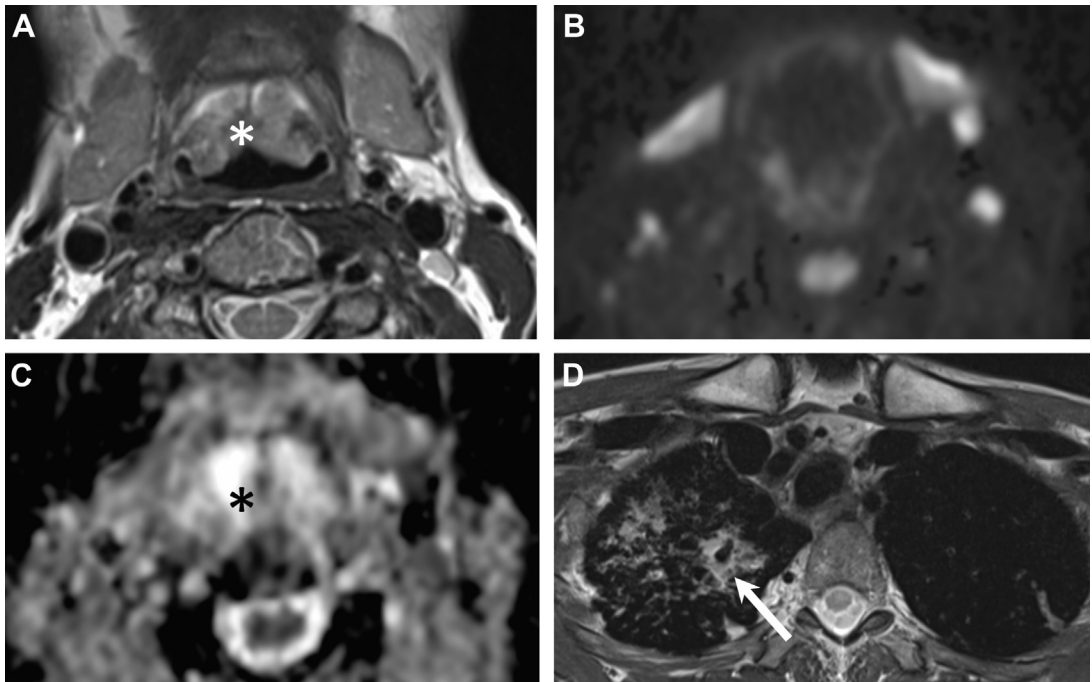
Tuberculosis of the supraglottic larynx with pulmonary involvement. Patient presenting with hoarseness increasing over several months and some weight loss. Fiberoptic endoscopy showed a bulky and ulcerated lesion of the epiglottis. Before biopsy, an MR imaging was obtained. Axial T2 (A) shows an epiglottic lesion infiltrating the pre-epiglottic space (asterisk). Corresponding b1000 image (B) and ADC map (C) show no restriction of diffusivity (asterisk in C) suggesting an inflammatory lesion. ADC was $1.6 \times 10^{-3} \text{ mm}^2/\text{s}$. Axial T2 image (from the same series as image A) at the level of the upper mediastinum (D) reveals characteristic right pulmonary involvement with cavern formation (arrow). The diagnosis of possible tuberculosis was suggested based on MR imaging findings. The diagnosis was confirmed.
